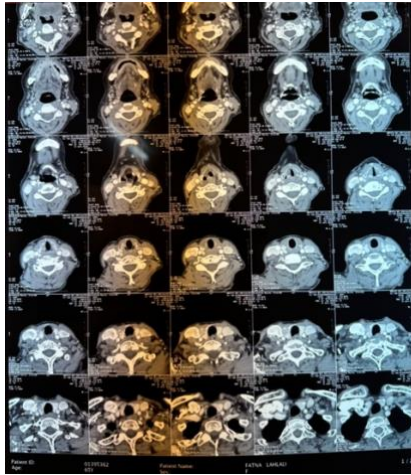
axial view of the CT scan
